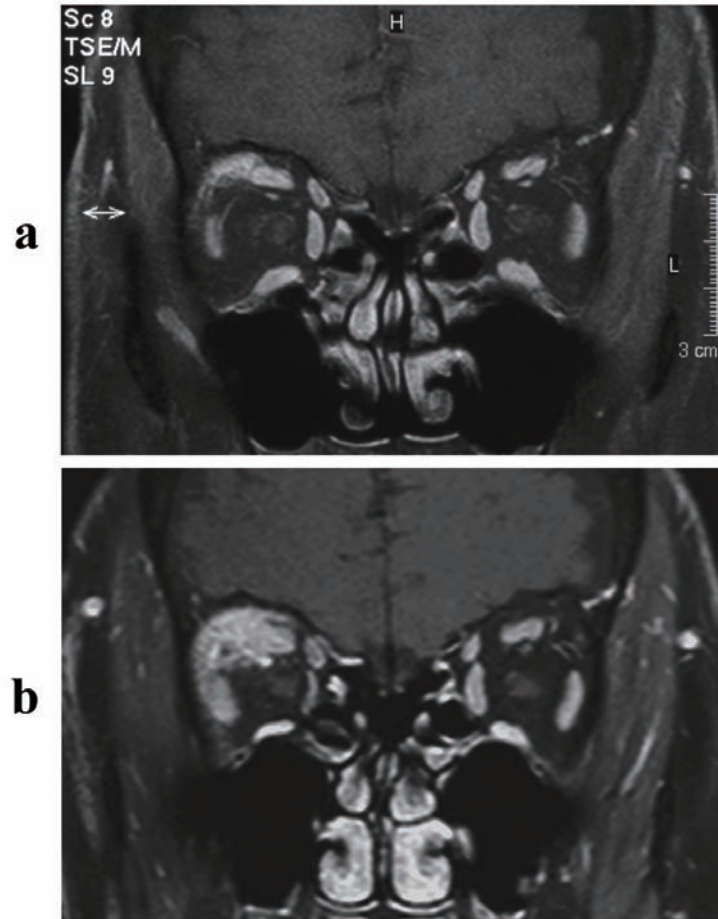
Radiological images. (1a) Enhanced magnetic resonance imaging (MRI) revealed right orbital tumor. (1b) The orbital tumor had gradually increased in size over 1.5 years.
